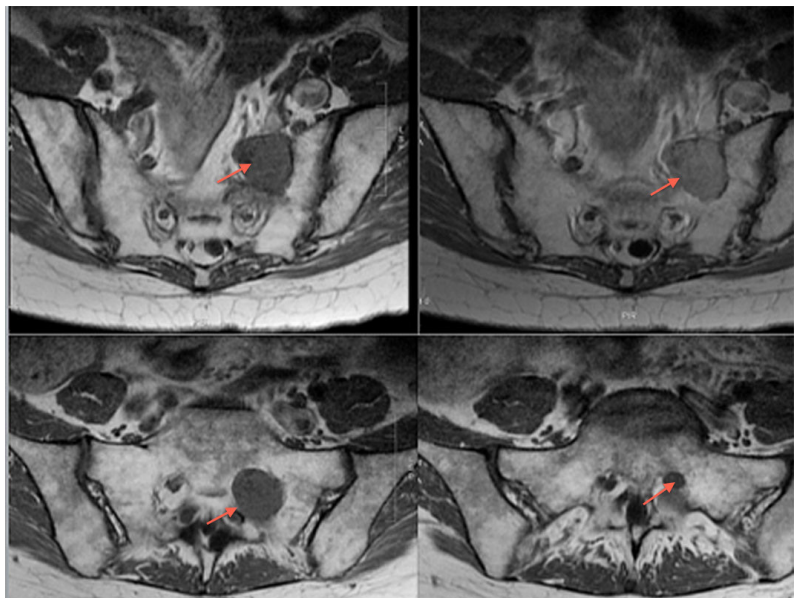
Axial images from the preoperative magnetic resonance imaging of the pelvis with gadolinium. Serial images define the superior-inferior extent of the tumor (arrow).
